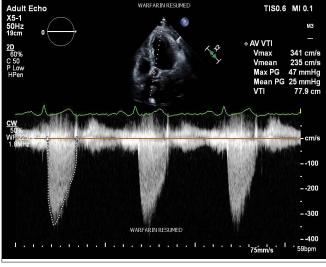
Echocardiography Doppler two weeks post anticoagulation.
